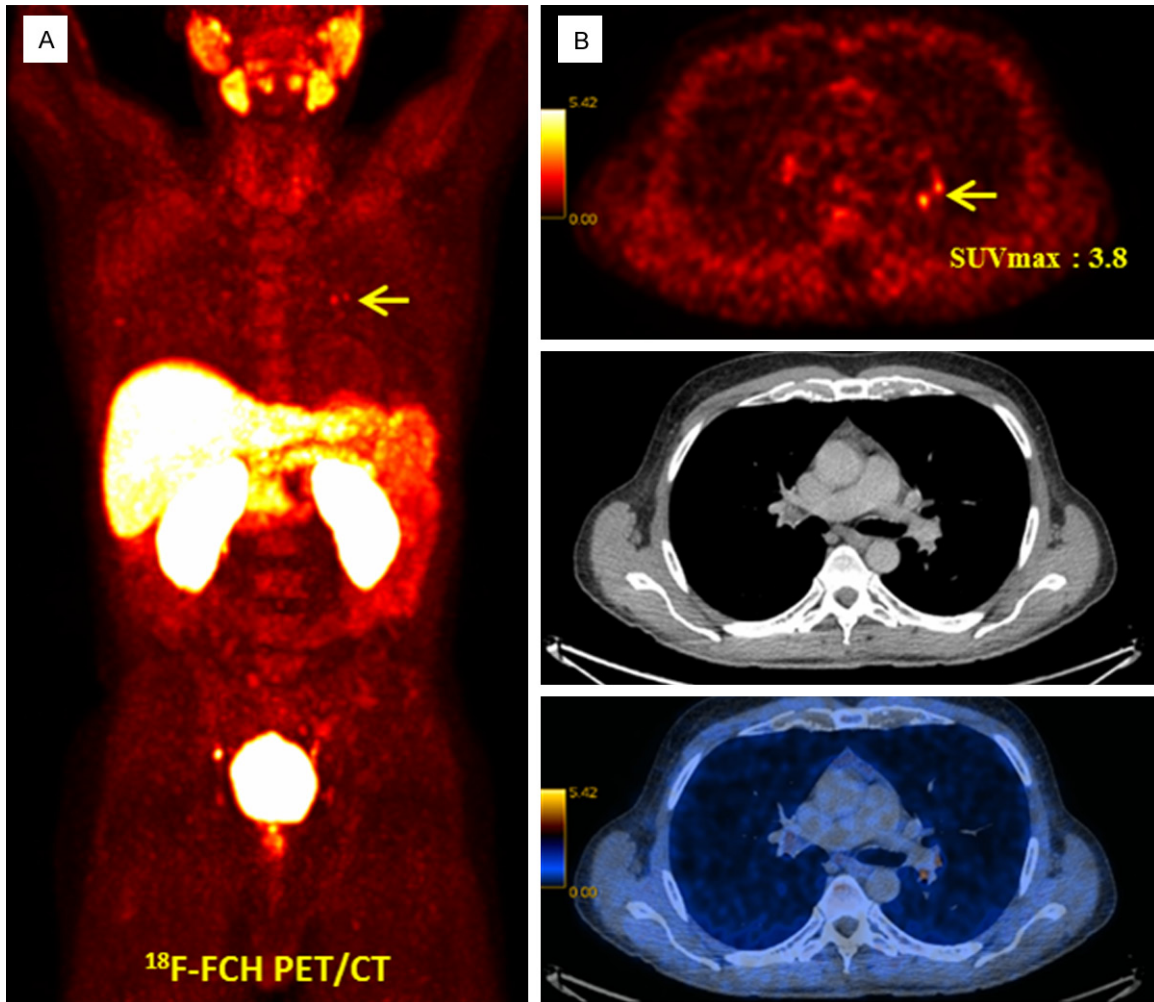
^{18}F -FCH PET/CT in a 58-year-old prostate cancer patient, Gleason score 7, PSA 22.3 ng/mL, increasing PSA under anti-androgen treatment after prostatectomy and radiotherapy (biochemical recurrence). A: ^{18}F -FCH PET MIP. B: Transaxial PET (upper row), CT (middle row) and PET/CT fusion (lower row). Mildly increased tracer uptake is visible in the left hilum arrow, SUVmax: 3.8)-suggestive of reactive lymph nodes verified as benign lesion in the follow-up clinical and imaging evaluation.
